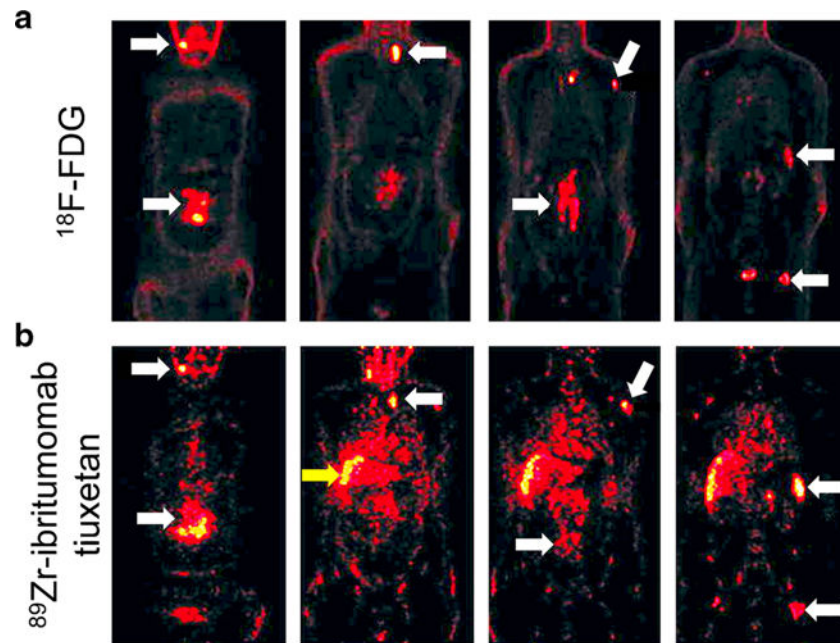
Comparison of ^{18}F -FDG and ^{89}Zr -ibritumomab tiuxetan PET imaging in a patient with NHL. a Coronal ^{18}F -FDG PET images obtained from the anterior (*left*) to the posterior (*right*). The cervical, mediastinal, splenic, left caput humeri, para-aortic, and inguinal lymph nodes are clearly visualized (*white arrows*). b ^{89}Zr -ibritumomab tiuxetan PET images obtained 96 h after tracer injection. The same lymphoma sites are visualized using this tracer (*white arrows*); however, liver uptake (*yellow arrow*) was attributed to the retention of ^{89}Zr after catabolism of the tracer. Reprinted with permission [117]
